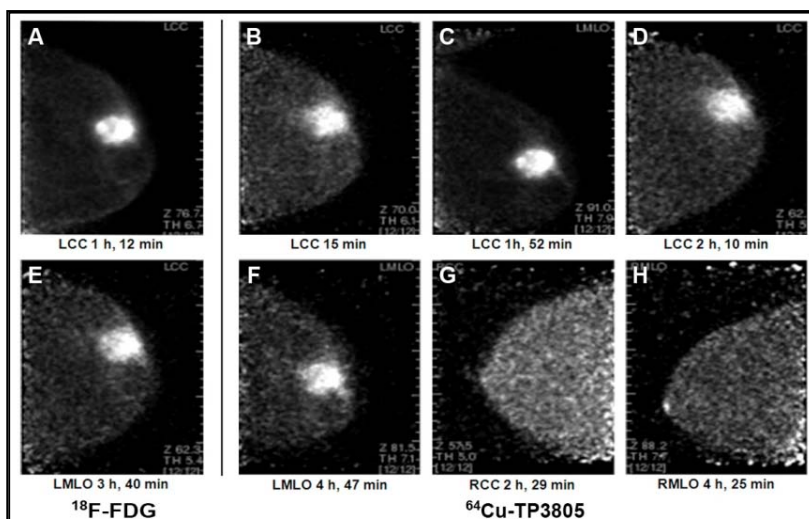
c. F-18-FDG (A, 370 MBq, (10 mCi) and Cu-64-TP3805 (B, 159.1 MBq, (4.3 mCi), F-18-FDG equivalent 860 μ Ci) PEM scans of the left breast of a 39 yr old female. The F-18-FDG scan was obtained 1 hr post injection and the Cu-64-TP3805 scan was acquired 15 min post injection. The PUV/BGV ratios for the lesion (IDC, ER+, PR+, HER2-) were 2.9 for F-18-FDG and 2.2 (lowest of the series) for Cu-64-TP3805.
